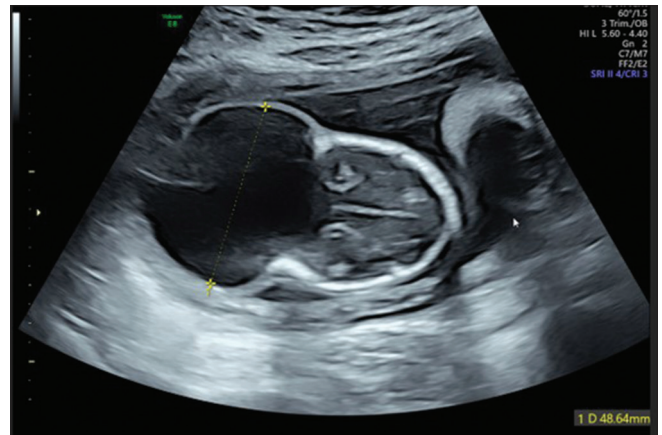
Second-trimester ultrasound of twin B (axial plane), showing progressively severe encephalocele at 19 weeks of gestation
